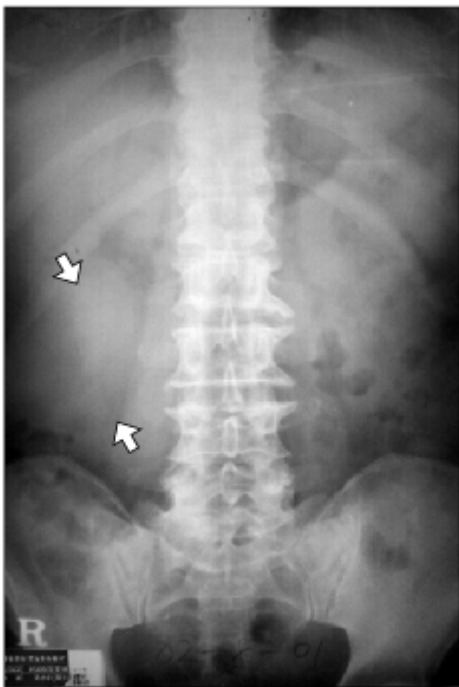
Plain film of the abdomen showed a large ovoid homogenous opacity mass (arrow) in the Rt. upper abdomen.
